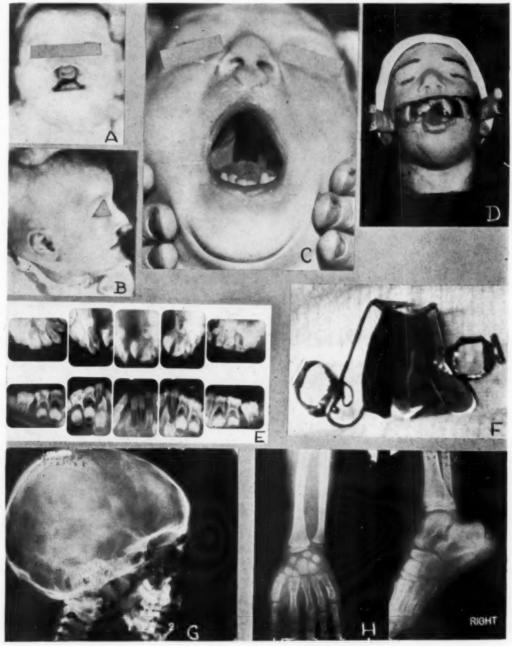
A, Front view of baby with bilateral cleft of lip and palate. (Courtesy of Carl G. Burdick, M.D.) B, Profile view of baby with bilateral cleft of lip and palate. (Courtesy of Carl G. Burdick, M.D.) C, Cleft of hard and soft palates before palate repair and revision of lip (still to be done). D, Moulage showing repaired hard and soft palates. E, Full mouth x-ray series revealing cleft on left side to be deeper and wider than on the right, also active calcification of right lateral incisor. Central incisors are at right angles to normal tooth axis. F, Photograph of appliance combined with obturator. G, Profile x-ray of skull. H, X-ray of wrist shows normal osteogenetic development. X-ray of ankle reveals the beginning of ossification of epiphysis of os calcis.
